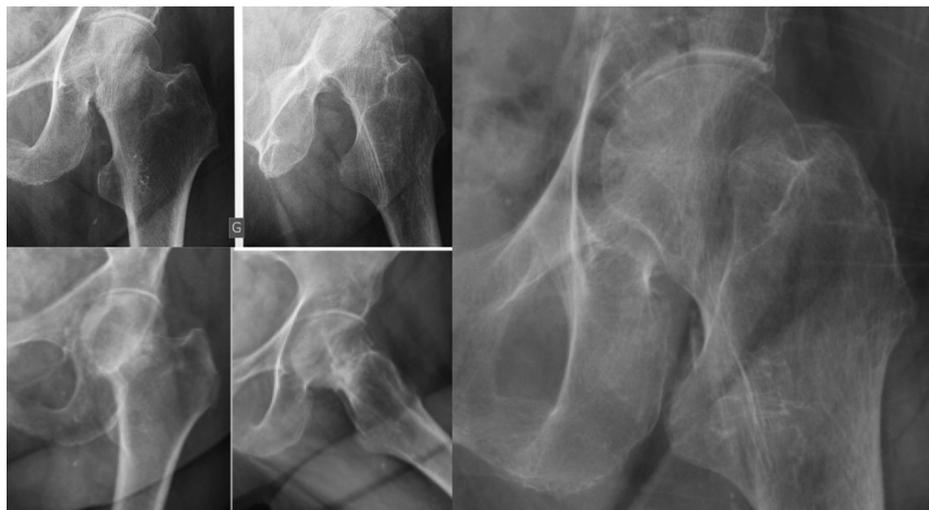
Radiographs taken at admission then 1 and 5 years later in a 77-year-old woman with a Garden I fracture on the left hip.
